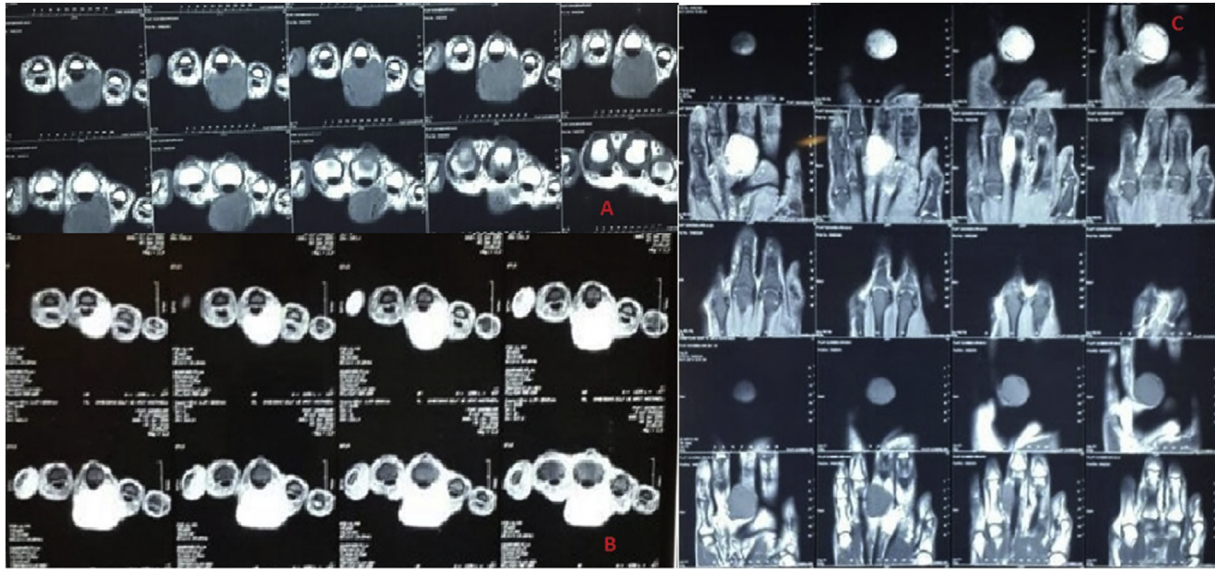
MRI views of the mass. A: T-1 weighted sequence, B: T-2 weighted sequence, C: T-2 weighted sequence.
